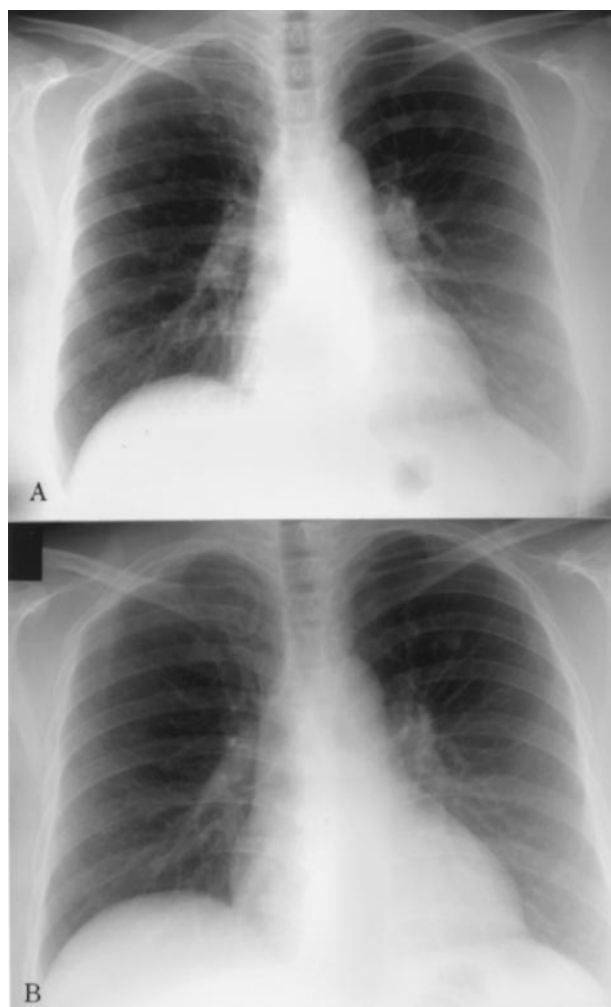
(A) Chest X-ray before therapy with a weekly 1-h paclitaxel regimen. Bilateral multiple metastatic lung tumors are found. (B) Chest X-ray after one course of paclitaxel. They are diminished in partial response.
